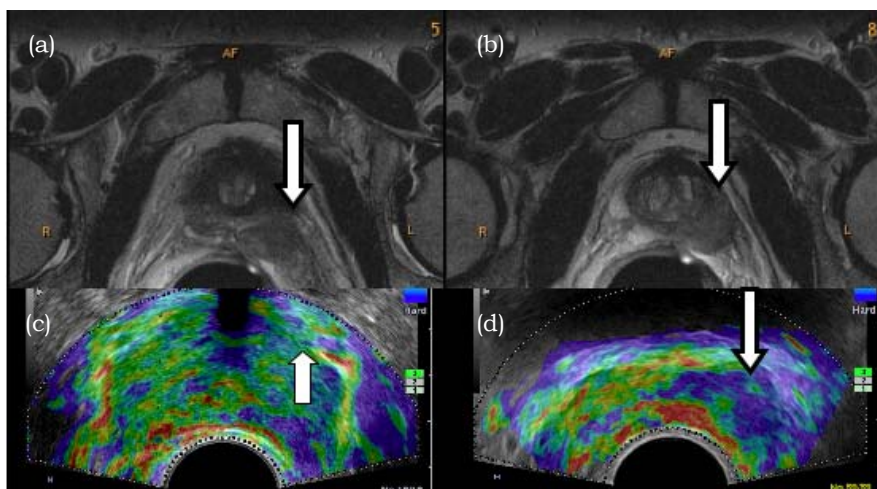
(a) and (b) MRI Images
